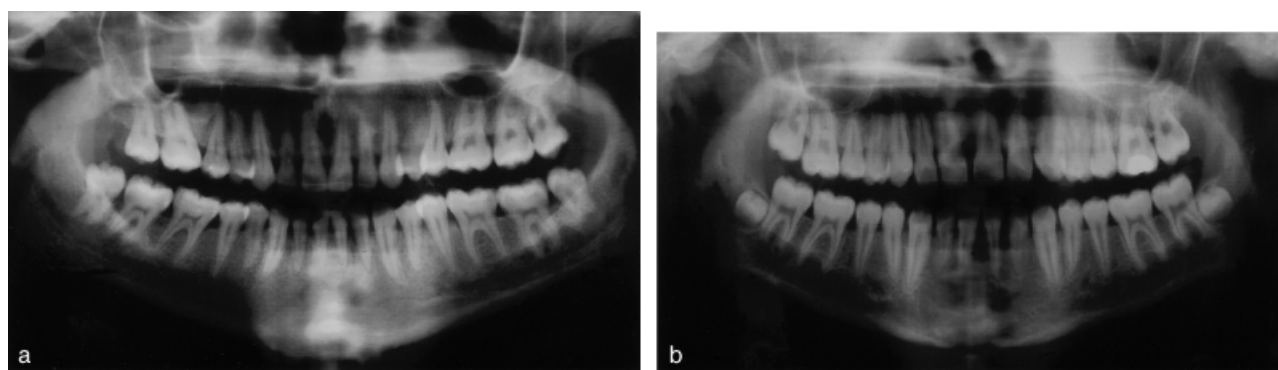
(a) Panoramic radiography of Case 1 and (b) panoramic radiography of Case 2.
